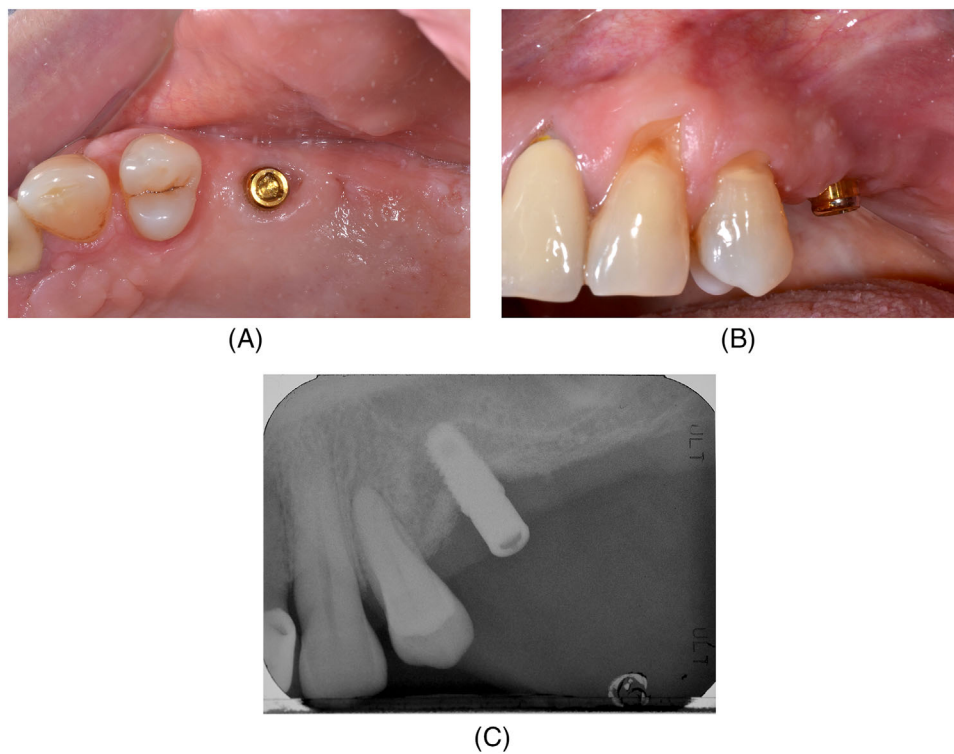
At the 2.5-year clinical (A, B) and radiographic (C) follow-up after prosthetic abutment re-insertion, both hard and soft tissue remained stable.
